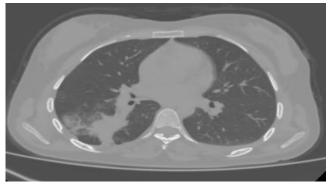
Chest computed tomography showed an area of parenchymal consolidation in the superior segment of the upper right lower of the lung
